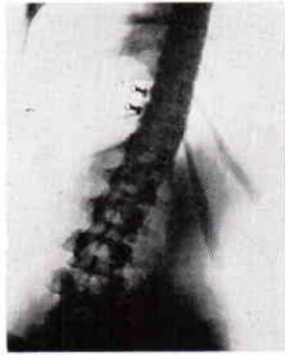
Same patient's spine x-rays as in Fig 8, but now wearing scoliosis harness. Note additional correction due to habitual reflex contraction of right lateral torso muscles.
